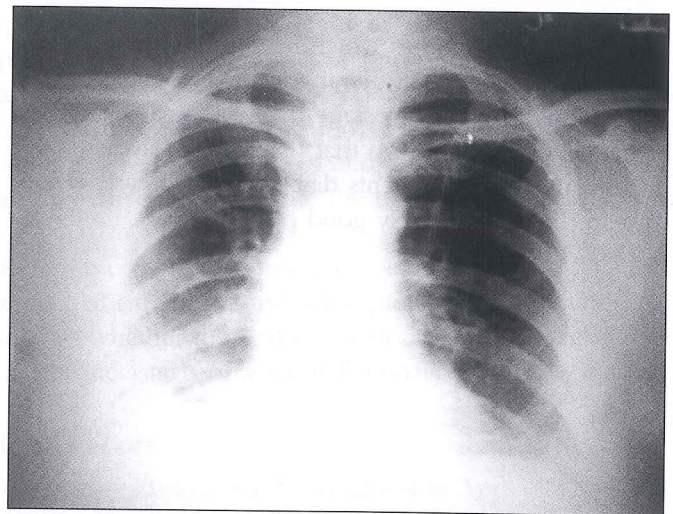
Chest radiograph after right lower lobectomy.
